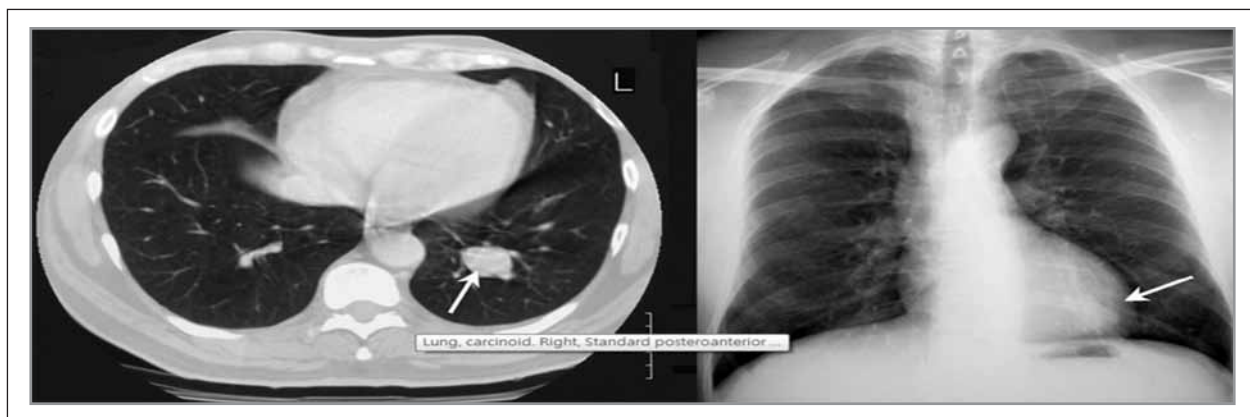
Plain Chest X-ray and High resolution CT scans (lung window) shows a well-defined round, partially endobronchial nodule (arrow) in the lateral subsegmental branch of the anterior segmental bronchus of the left upper lobe. (c) On a contrast-enhanced CT scan (mediastinal window) the nodule (arrow) demonstrates marked contrast enhancement and mimics a vascular structure
